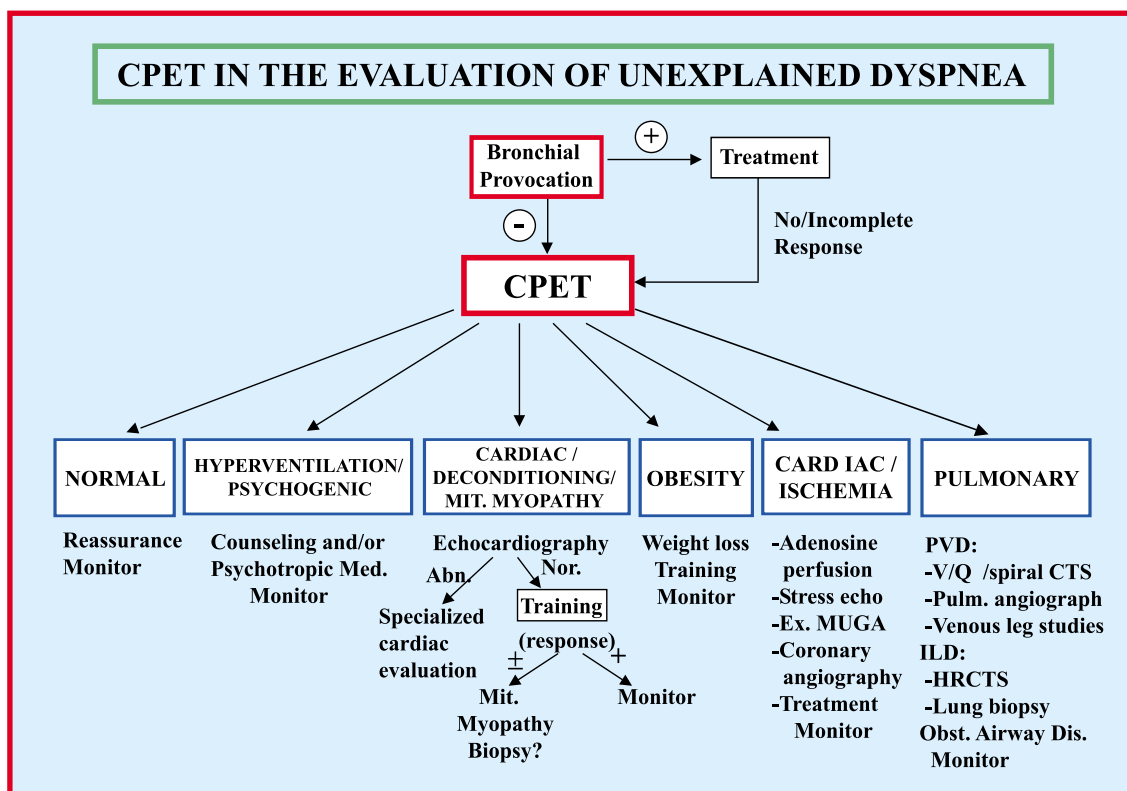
Results from CPET which may help guide subsequent evaluation of unexplained dyspnea. CPET = Cardiopulmonary exercise test; ILD = interstitial lung disease; HRCTS = high-resolution computed tomography scan; PVD = pulmonary vascular disease; V/Q = ventilation/perfusion, +/- or incomplete resolution on the arm under treatment [from 39, with permission].
